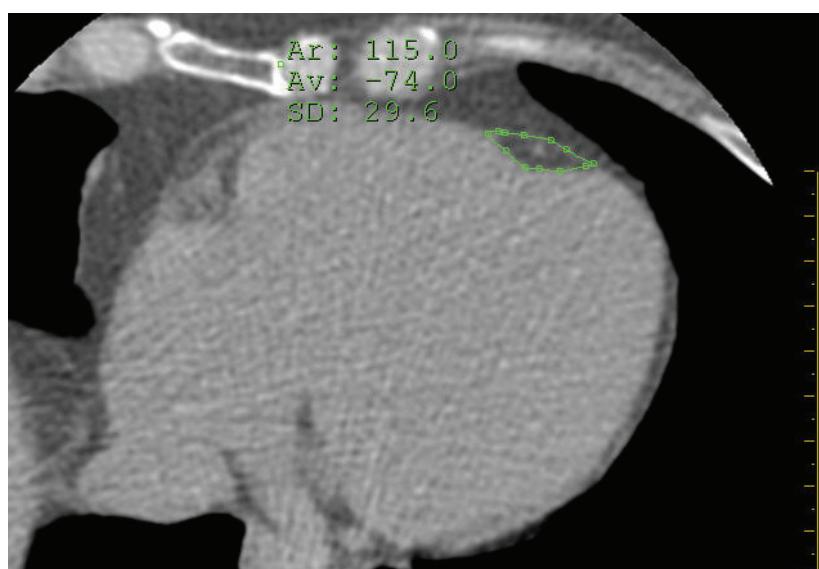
Multi-detector CT of the heart. The above CT calcium scoring scan shows the pericardium with underneath it the epicardial adipose tissue (EAT) surrounding the left anterior descending coronary artery (LAD). At this level the area measurements of EAT in the LAD area can be done perpendicularly to the heart.
